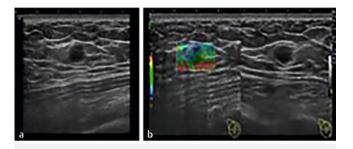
a Myofibroblastoma. Hypoechoic focal finding without increased perfusion on ultrasound. b Hard representation on elastography.
